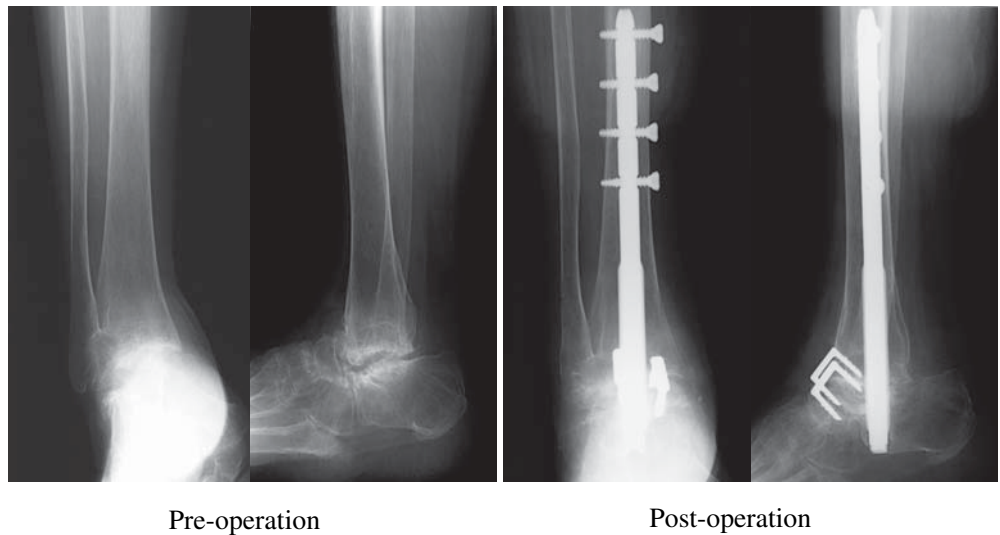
Case 1, a 51-year-old woman with rheumatoid arthritis. Preoperative and 3-year postoperative radiographs. Talocrural and subtalar joints show almost fibrous ankylosis and destructive changes. She is relatively young and has high activity in daily life. This case was considered as a good indication of an ankle arthrodesis. Total ankle scores improved from 53 points before surgery to 73 points 3 years after surgery
